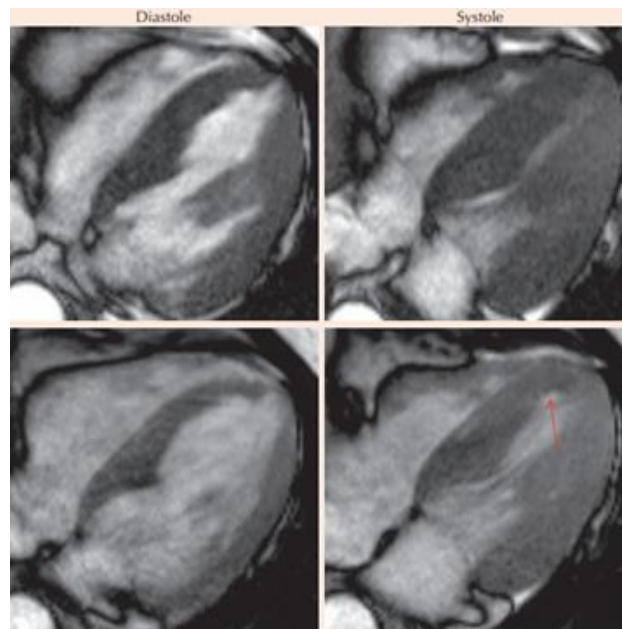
Four Cavity Cine-MRI imaging, recorded before (high) and after stress (low), shows the appearance of septo-apical akinesia, reinforcing the presence of a severe lesion of the left anterior descending coronary
